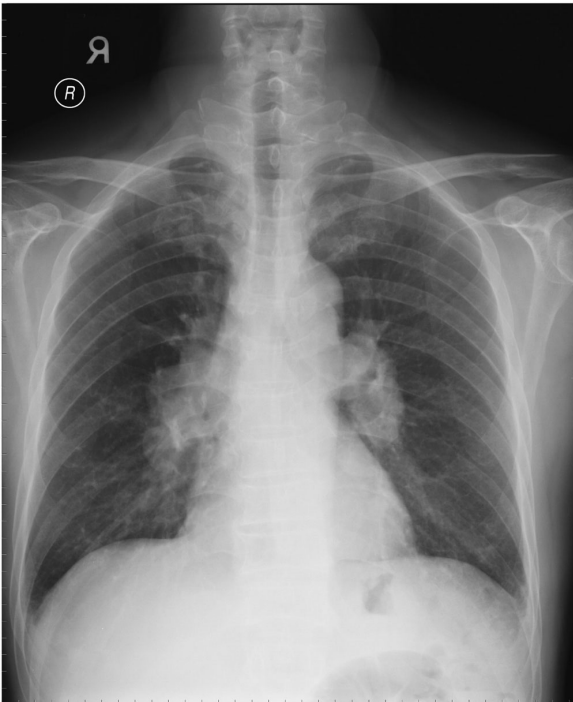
The posteroanterior view of chest X-ray shows typical hilar and paratracheal lymphadenopathy and a pattern of irregular pulmonary parenchymal involvement.
